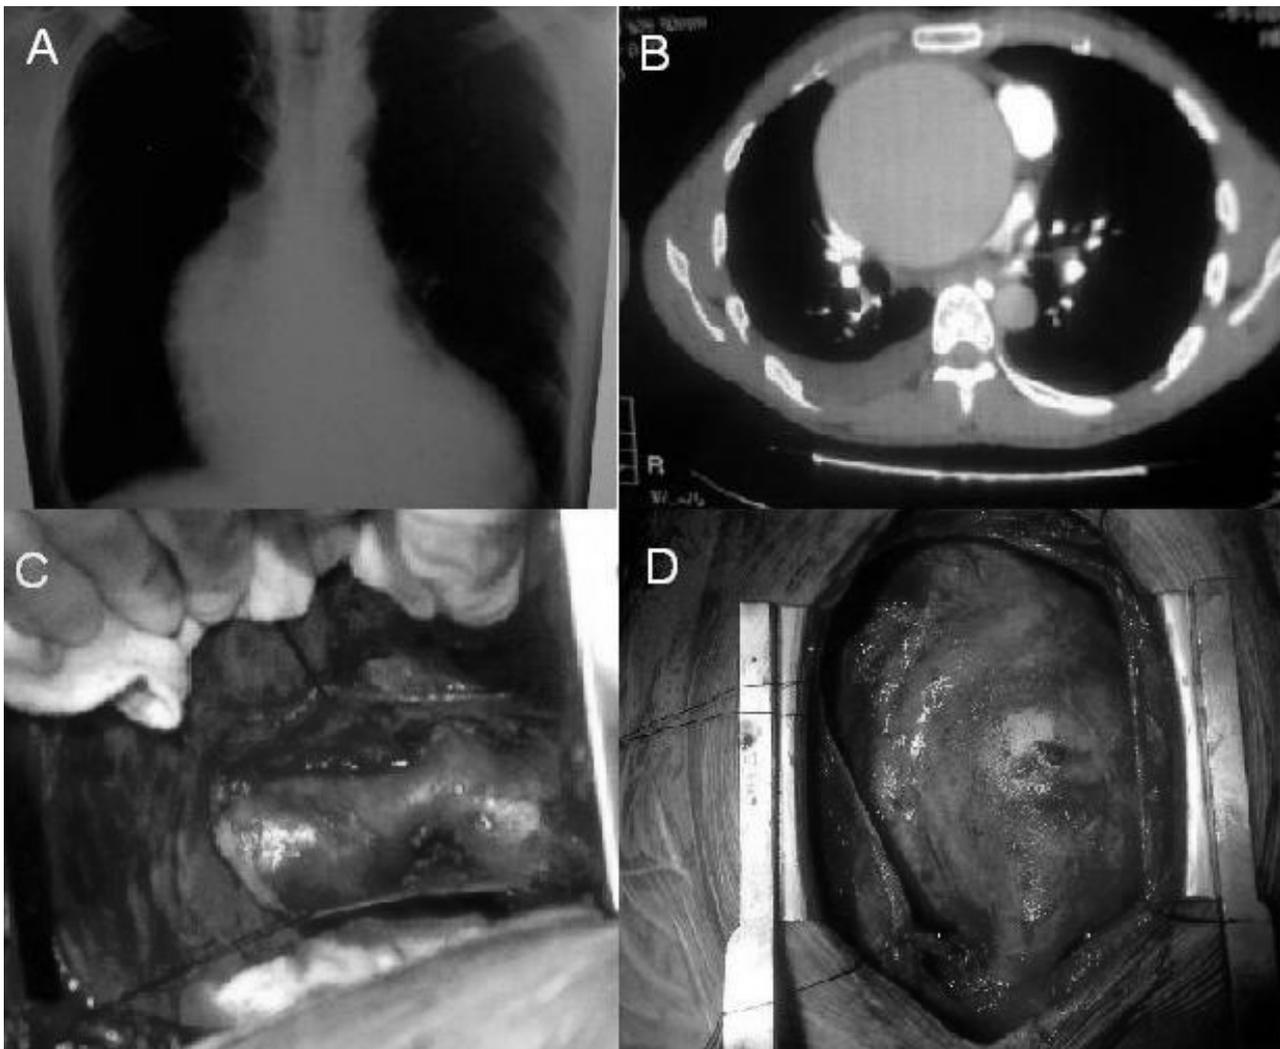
Chest radiography showed rib notching and very large mediastinal site.
